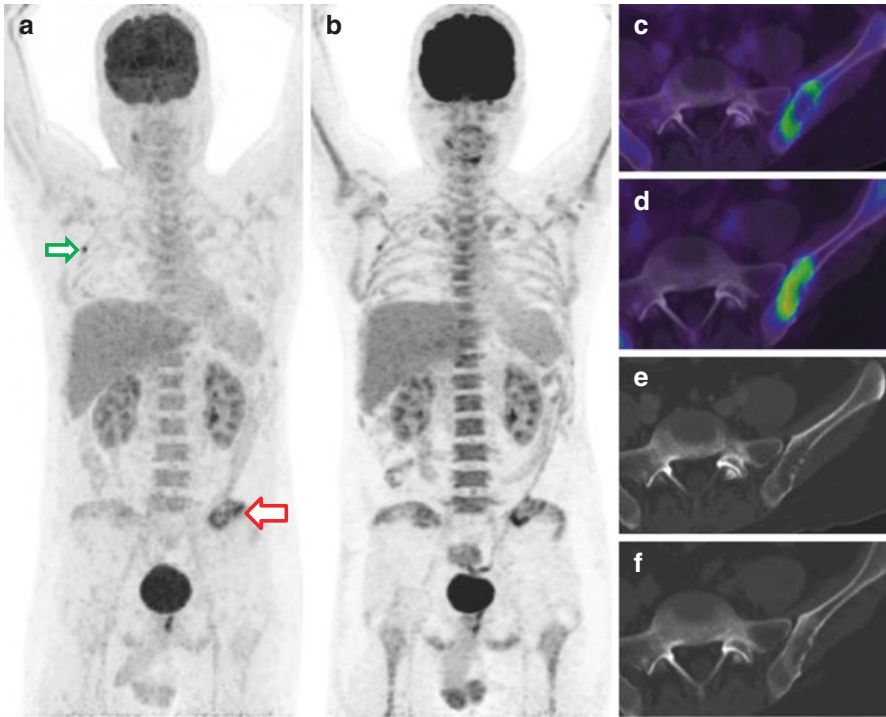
A 56-year-old man who is a treated case of carcinoma of the rectum (surgery and adjuvant chemoradiation) on follow-up had rising CEA levels. ^{18}F FDG PET/CT (a - MIP) for suspected recurrence evaluation revealed increased FDG uptake in the left iliac bone (*red arrow*) and right third rib (*green arrow*). Biopsy from left iliac bone confirmed the metastasis, and he underwent three cycles of chemotherapy. ^{18}F -FDG PET/CT for response evaluation (b) shows diffuse FDG uptake in marrow due to reactive changes sparing the RT field in pelvis. Pretreatment FDG uptake in the left iliac bone (c), and corresponding lytic lesion (e) is noted. Careful observation and interpretation of findings are required as posttreatment FDG uptake is increased (d) with development of mild sclerotic changes in the left iliac bone lesion (f) and no new lesions are noted
